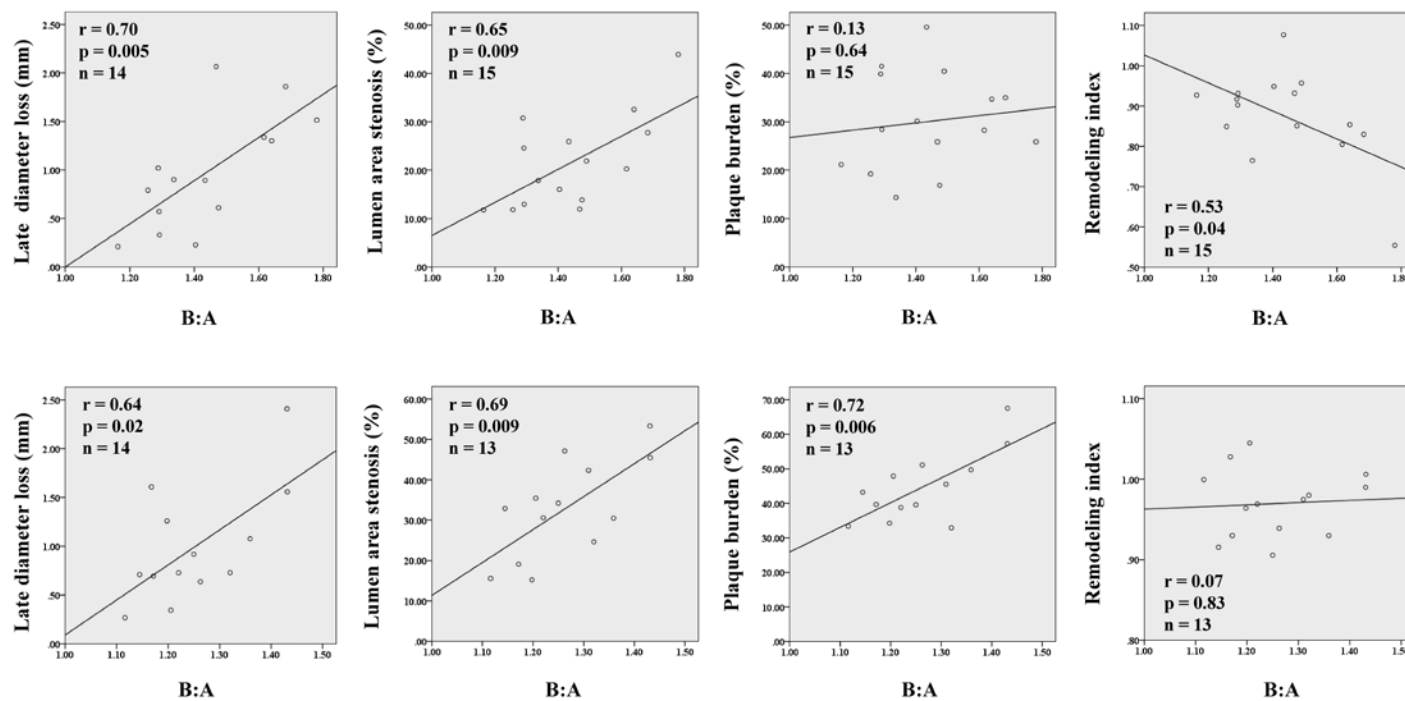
Correlations between balloon-to-artery (B:A) ratios and quantitative parameters assessed by quantitative coronary angiography and intravascular ultrasonography. Upper panels, balloon overstretch injury model; lower panels, stent overexpansion model.
